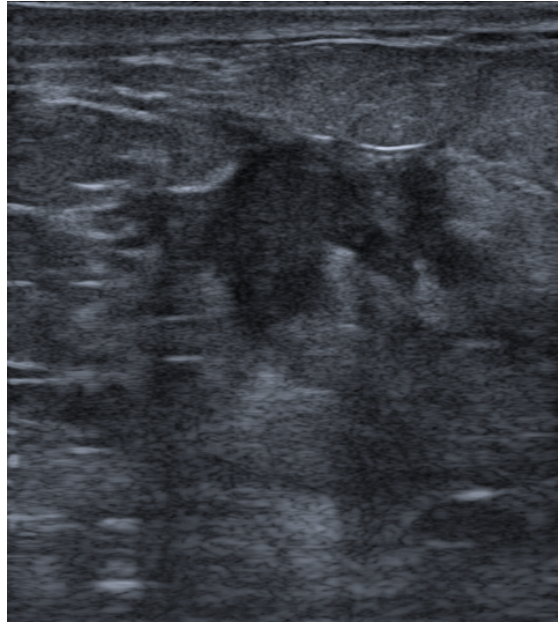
Example of a breast ultrasound image containing a lesion of invasive ductal carcinoma. Image from the dataset provided by Pawlowska et al. [63] under CC BY 4.0 [32].
